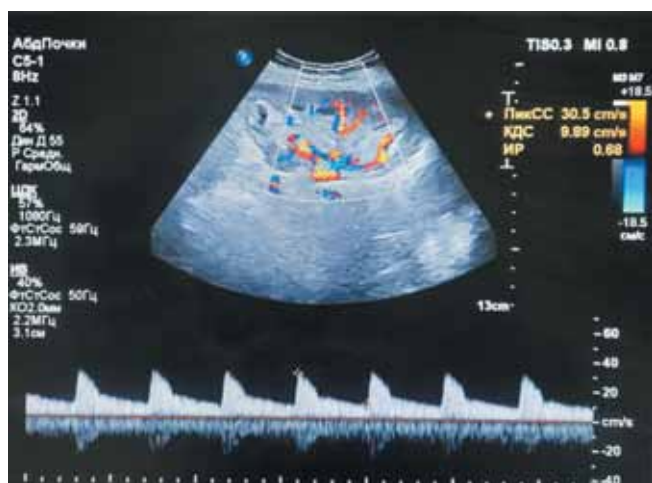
Ultrasonogram of the kidney graft (12 years after kidney transplantation). Resistive index in the segmental artery of the renal graft is within normal range
